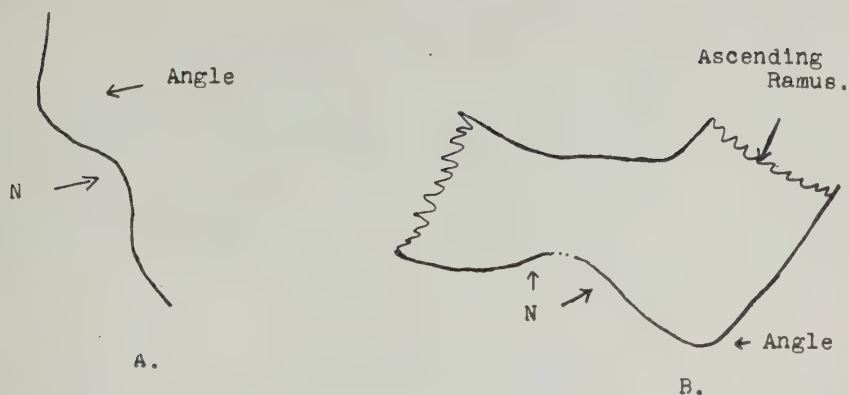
These outlines of the x-rays taken from same positions as in Fig. 1.
